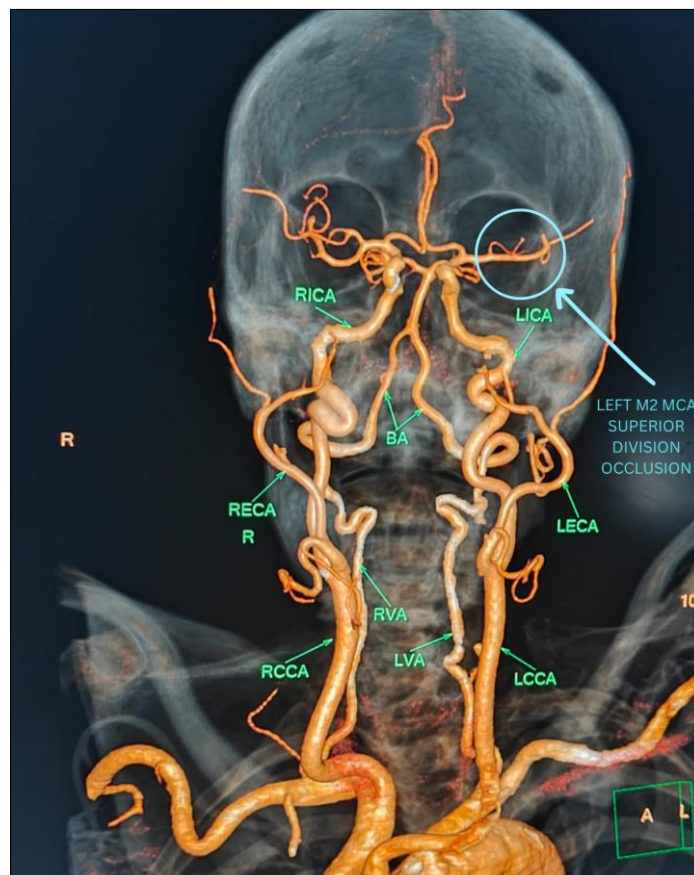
CT Angiography image showing cut-off in the superior segment of Left M2 MCA due to the thrombus
